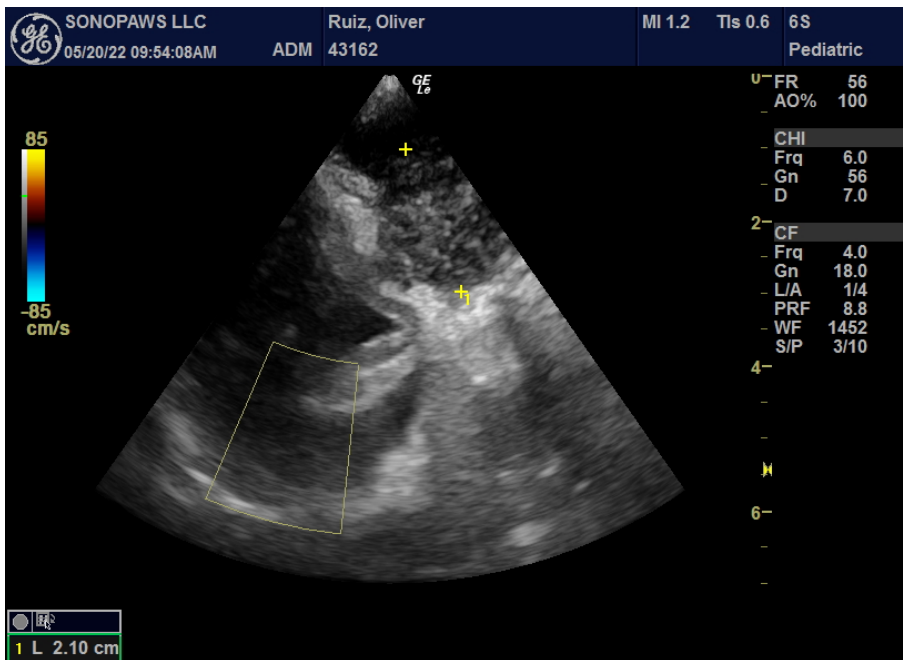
Left parasternal view of the normal right atrium and auricle. The mass is partially seen and does not appear to involve the right atrium or auricle.
